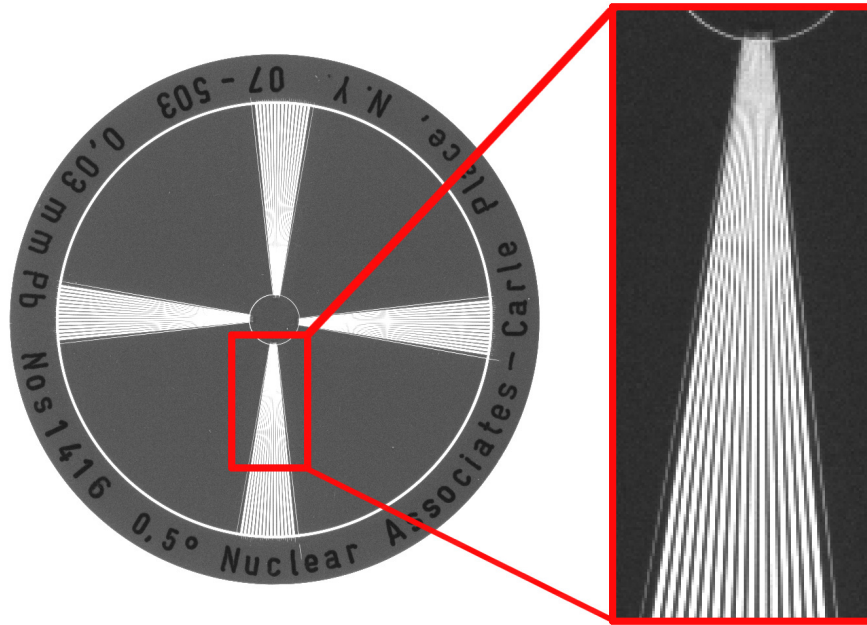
An example of signal aliasing in an x-ray image of a star-pattern acquired with a clinical mammography system. At the center of the image where spacing between bars is less than the pixel size, a distinct Moiré pattern is caused by aliasing. Additionally, there are aliasing artifacts producing steps along the spoke edges caused. The x-ray image of the star pattern was provided courtesy of Dr. Jan Linsdström.
